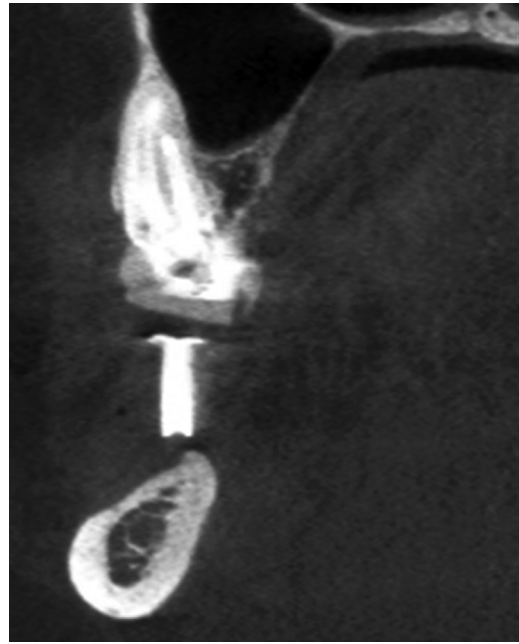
Cone-beam computed tomography view.
